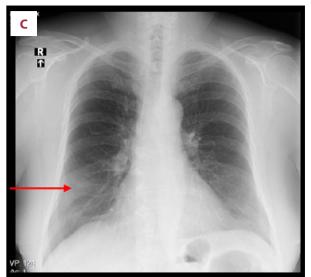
CT scans (A: pulmonary window, B: mediastinal window) of the chest and thoracic X-ray (C) of a patient with tuberculosis granuloma. In A) and B), red arrows point out a peripheral nodule with the dimensions of 24×13 mm in the right lung. In C), red arrow indicates parenchymal densities size 77×65 mm in the lower field of the right lung.
